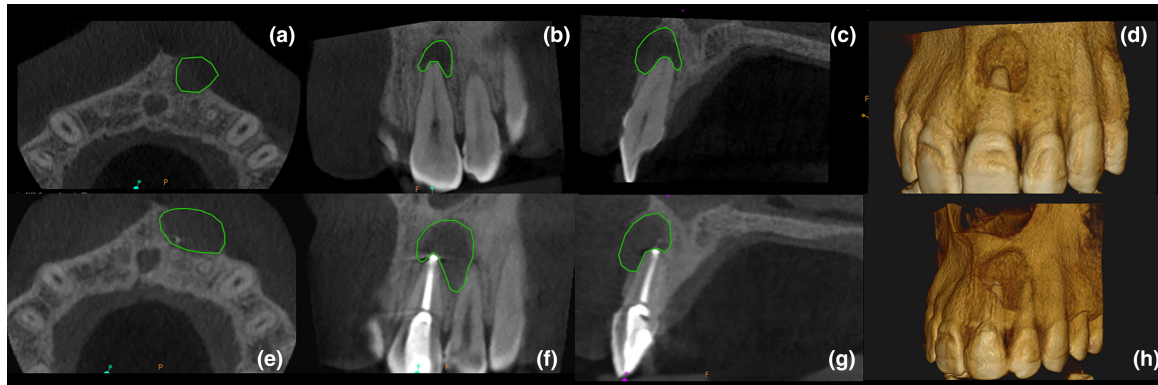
Multiplanar reconstructed CBCT images of an unhealed case at 12 months follow-up. Preoperative (a–d), 12 months follow-up (e–h).
